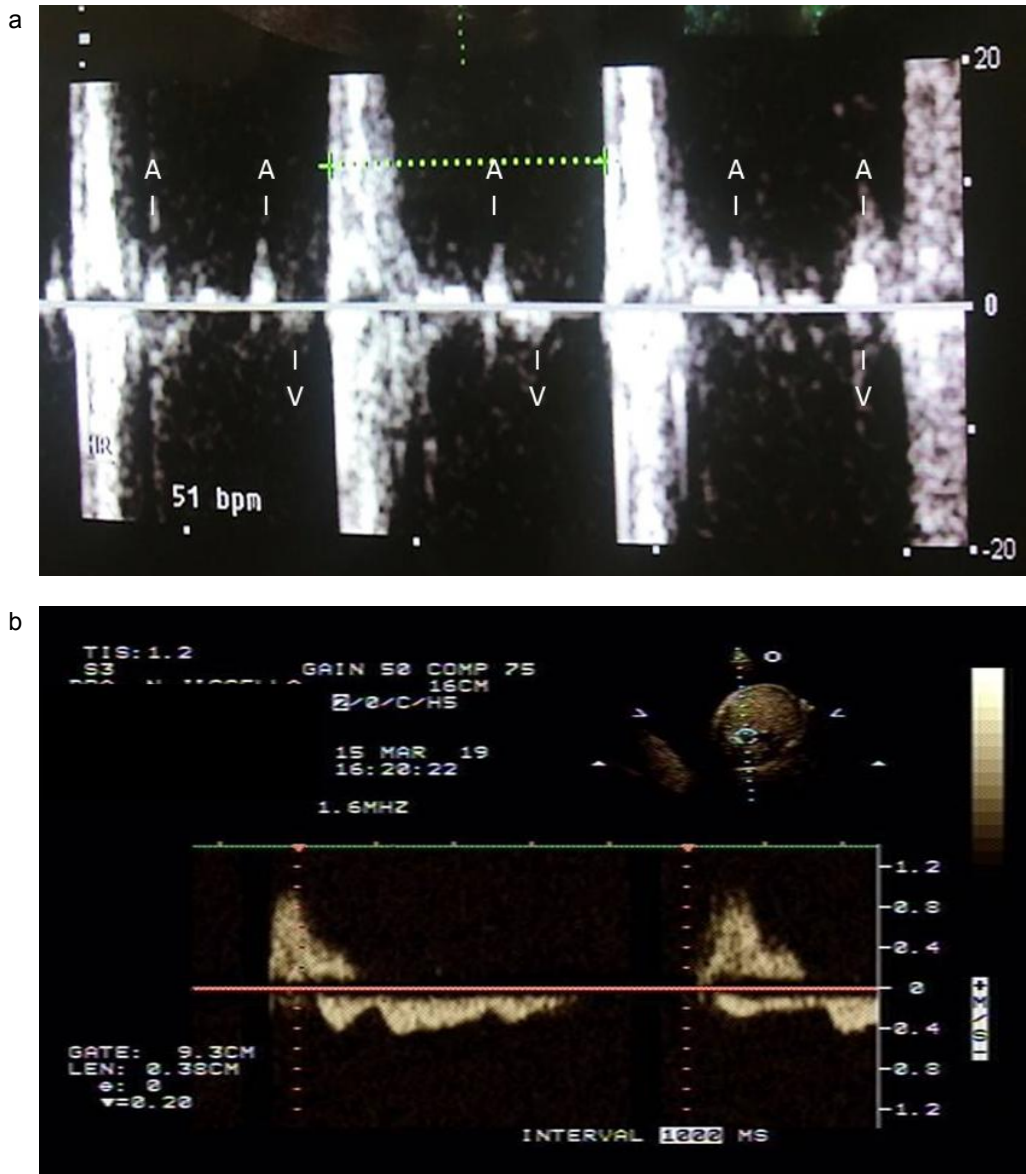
Pulsed-wave Doppler US with a fetal heart rate of 51 beats per minute; A, atrial; V, ventricular. (a); fetal P-R interval of 1,222 milliseconds confirms the diagnosis of complete congenital atrioventricular block (b).
